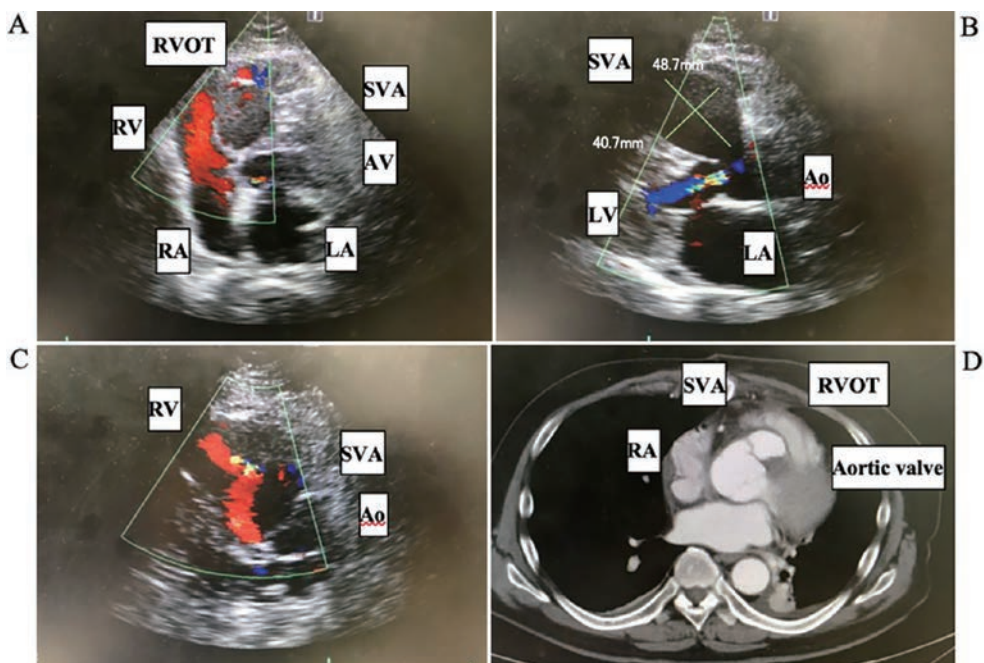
Preoperative transthoracic echocardiography. The sinus of Valsalva protrudes significantly into the right ventricle, and the right ventricular outflow tract is narrow (A). The sinus of Valsalva aneurysm is 48.7 mm in diameter and has a minor axis of 40.7 mm and there is backflow into left ventricle (B). TTE about a week after operation showed blood flow into the SVA and into the right ventricle (C). CT performed at the same time showed inflow of contrast into the sutured sinus of Valsalva (D).
